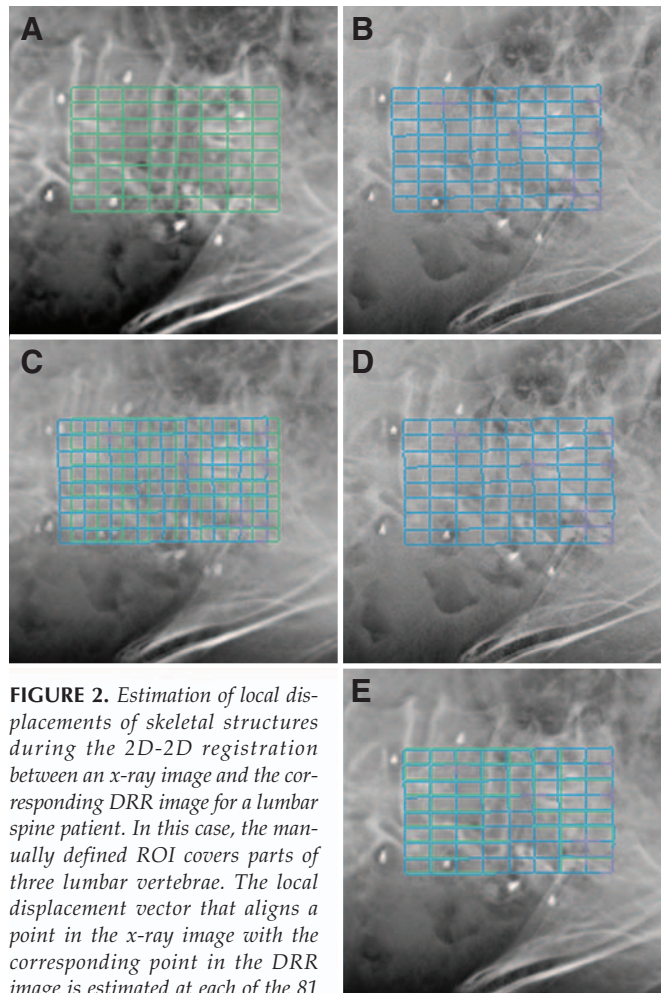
Estimation of local displacements of skeletal structures during the 2D-2D registration between an x-ray image and the corresponding DRR image for a lumbar spine patient. In this case, the manually defined ROI covers parts of three lumbar vertebrae. The local displacement vector that aligns a point in the x-ray image with the corresponding point in the DRR image is estimated at each of the 81 node points in a 9×9 regular grid that covers the region of interest. Each node point is the intersection of two grid lines in the mesh. A, DRR image with overlaid grid. B, x-ray image with overlaid grid before initial patient alignment. Each node point corresponds to a node point in the regular grid shown on the DRR image in A and was determined by translational block matching. C, a combination of the DRR and x-ray images with overlaid grids before initial patient alignment. The images are combined by adding the corresponding pixel values. It is visually obvious that the images are in poor alignment. The skeletal features show up in pairs in the combined image. The two grids are misaligned by a horizontal (superior-inferior) translation that is approximately one-half of the grid spacing. D, x-ray image after patient alignment. The treatment table was moved according to the patient misalignment computed by the Xsight tracking system from the 2D displacement fields. E, a combination of the DRR and x-ray images after patient alignment. The combined image is free of the types of artifacts that are seen when images are in poor alignment and the grids are in almost perfect alignment. This figure, as well as Figures 4 and 5, show magnified images from one of the two projection views. The Xsight user interface shows the DRR, x-ray, and combination images for both projection views in a 2×3 layout. The images can be displayed at various magnifications. The grid, the user-defined CT image coordinate system origin, and linked cross-hairs can each be optionally overlaid on the images.
